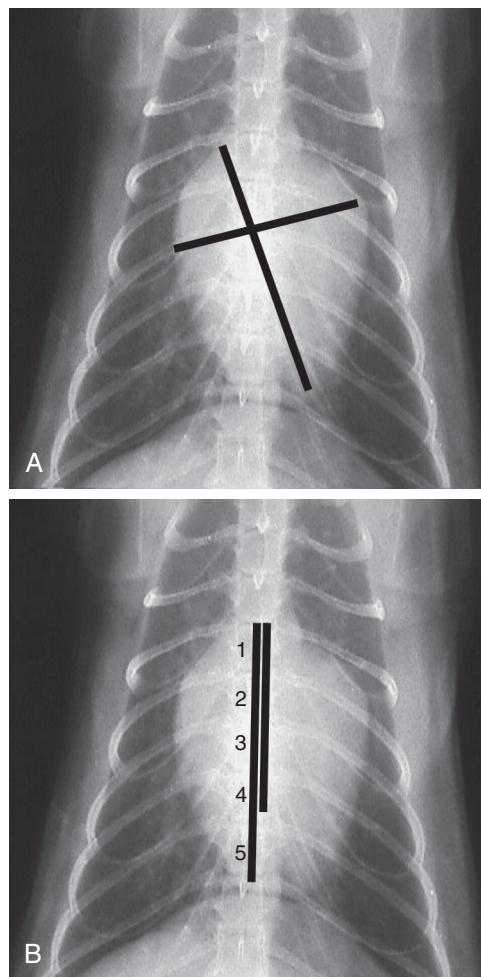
Measurement of vertebral heart scale on the dorsoventral radiographic view. A, A line is drawn along the long axis of the heart from right atrium to left ventricular apex. A second line is drawn perpendicular to the long axis, spanning the atria. B, These lines are then transferred to the cranial edge of the fourth thoracic vertebra, and the number of vertebrae spanned by the two lines is summed. In this example the vertebral heart scale is approximately 9 vertebrae.
